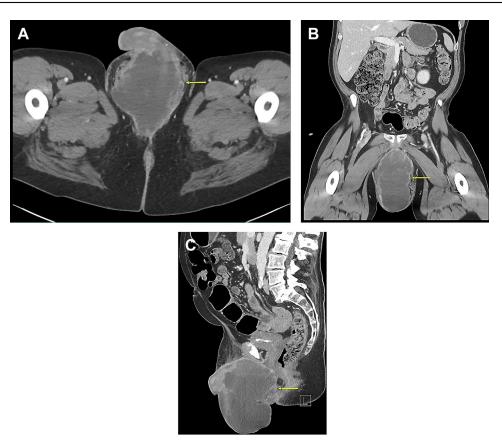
Computed tomography scans with (A) axial, (B) coronal, and (C) sagittal views. Yellow arrow identifies lesion. Tumor has solid and cystic components with loss of fat plane between the mass and anus.
